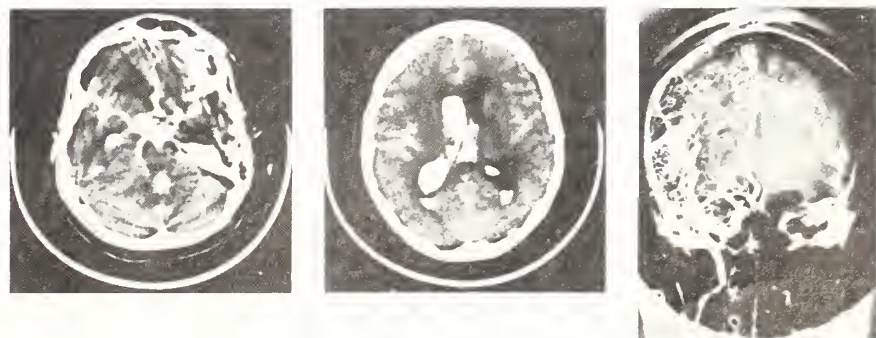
Left and middle - CT scans without contrast revealing massive subarachnoid hemorrhage and intraventricular hemorrhage. Right - Right A-P ICA angiogram revealing small ICA aneurysm projecting medially.
